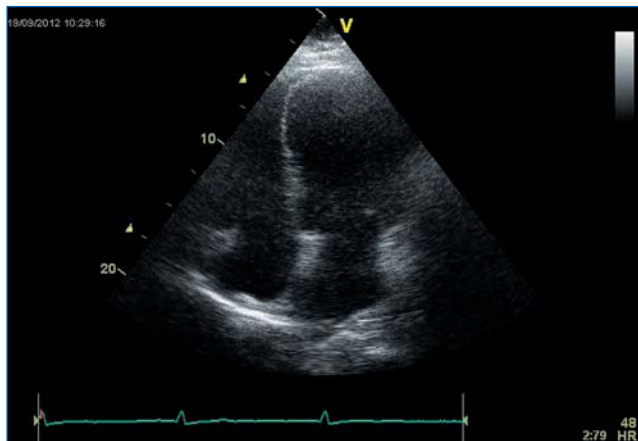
TTE apical four chamber view. Normal mitral valve and mild LA and LV enlargement.
